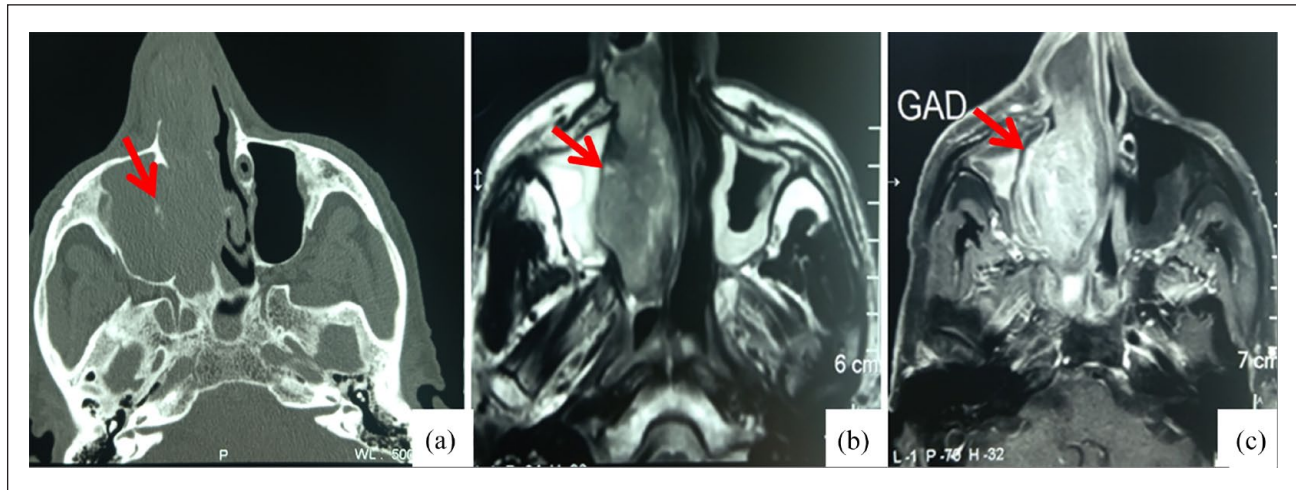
(a) Computed tomography scan (axial section): tumor (arrow) involving the right nasal cavity with bony erosion of the nasal septum and the medial maxillary sinus wall. (b) Magnetic resonance imaging (MRI) T2 sequence (axial section): tumor showing hypointense signal. (c) MRI T1 post-contrast (axial section): tumor showing enhancement.
